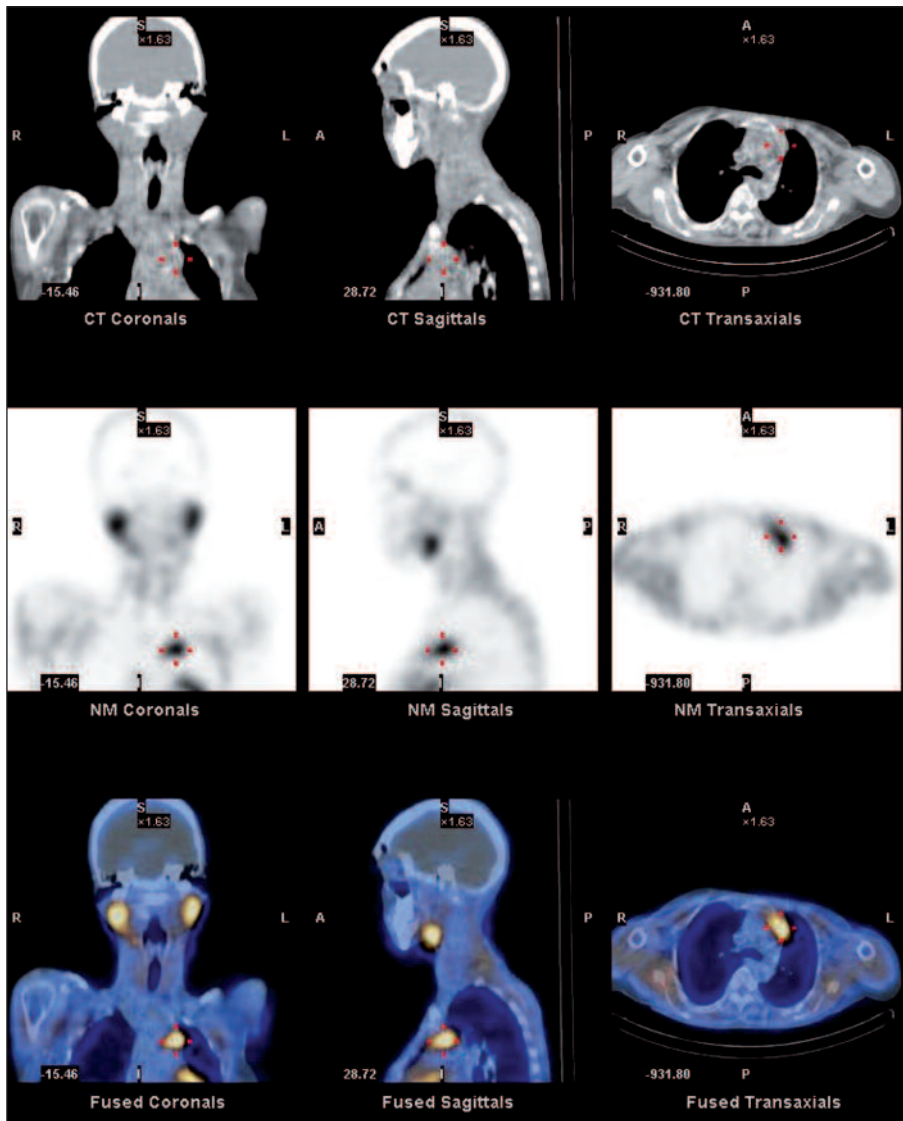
Parathyroid SPECT of the lesion seen in the mediastinum.
